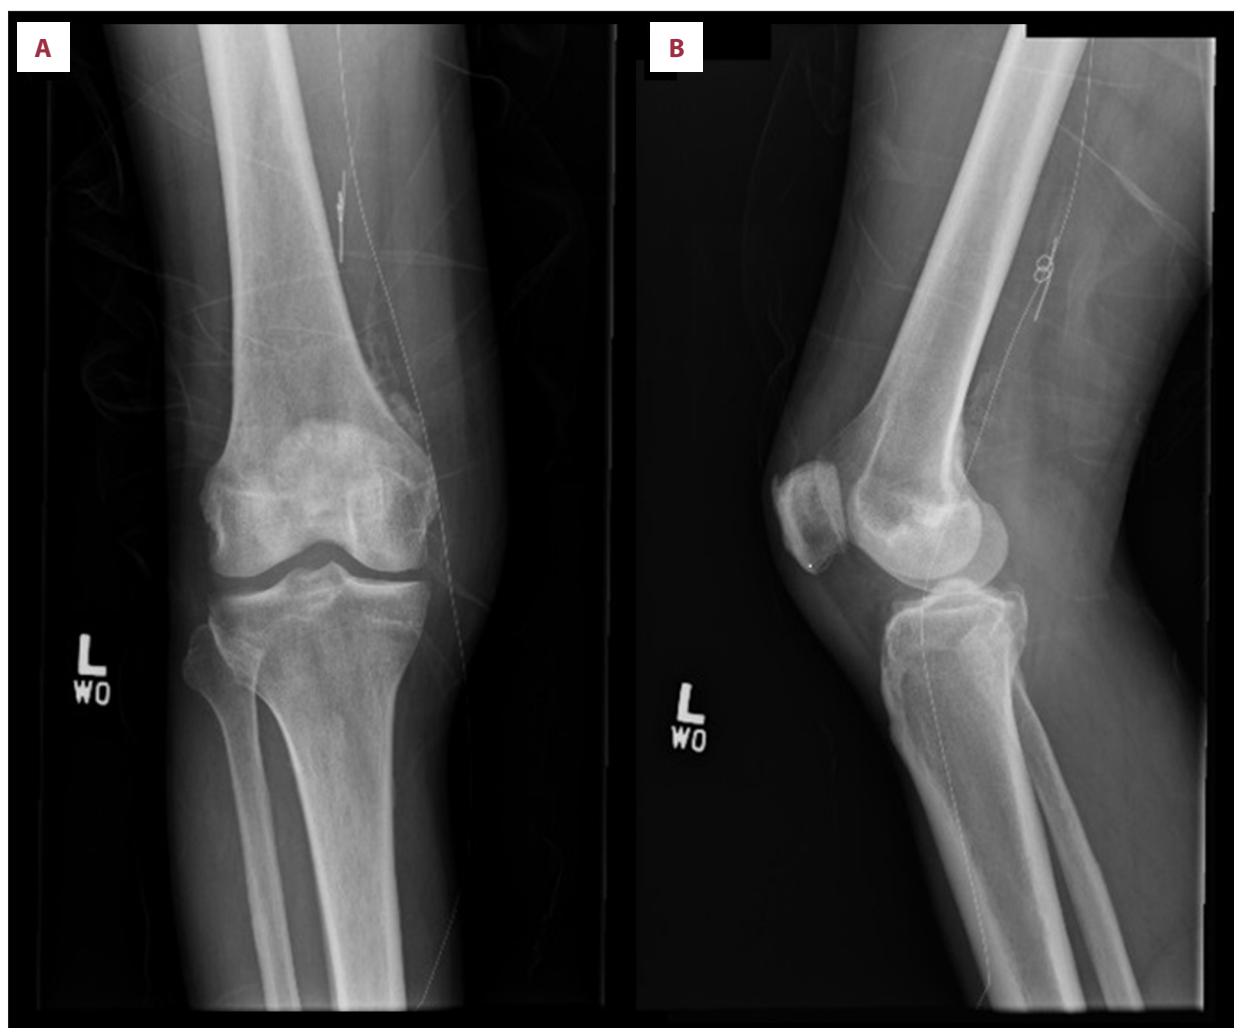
Anteroposterior and lateral X-radiographs of the right knee of a 52-year-old African-American man who presented with a retained venous guidewire. (A) Anteroposterior view and (B) lateral view shows a thin wire extending from the medial side of the right femur.
